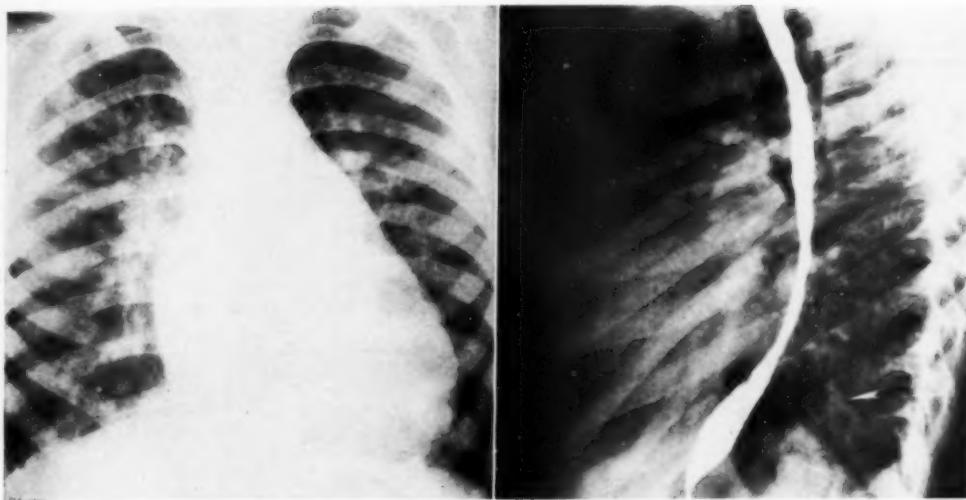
Roentgenograms of chest of four-year-old child with ductus 8 mm. in diameter, demonstrating "typical" appearance of heart and pulmonary vasculature.
